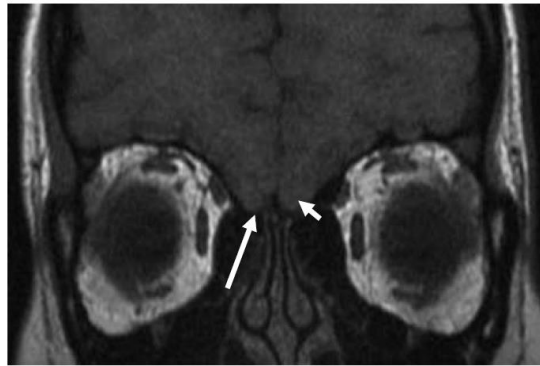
T1-weighted magnetic resonance imaging: bilateral olfactory bulb agenesis (long arrow) with aplastic olfactory sulci (short arrow).
